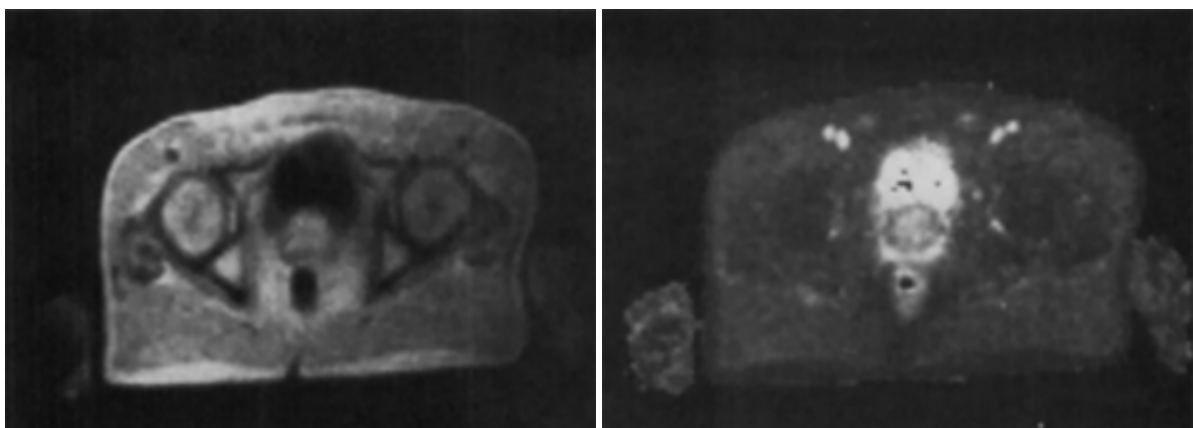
¹³: Proton density–weighted MR image shows BPH with prostate outlined between bladder and rectum.
